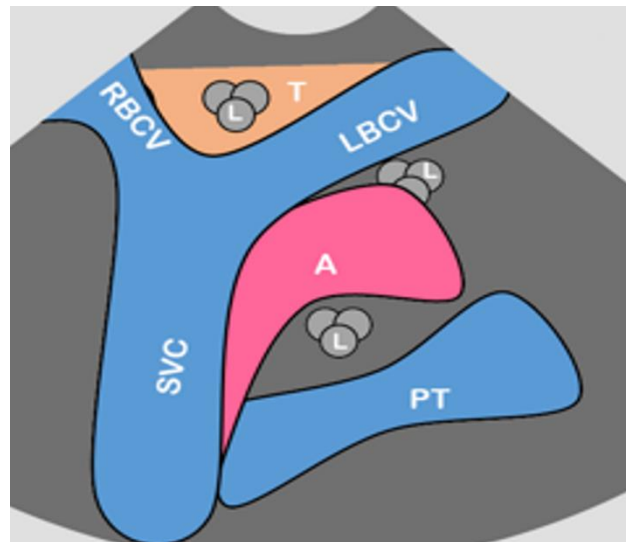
Predefined zones in the transverse suprasternal view in ultrasound. A - aortic arch; L - lymph node; LBCV - left brachiocephalic vein; PT - pulmonary trunk; RBCV - right brachiocephalic vein; T - thymic region
